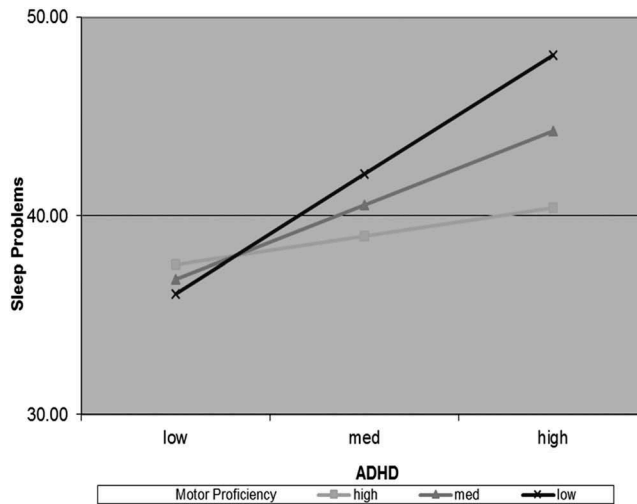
Whole sample (ADHD-CT+ TD) ADHD symptoms severity and sleep problems moderated by motor proficiency (without mean centering).
